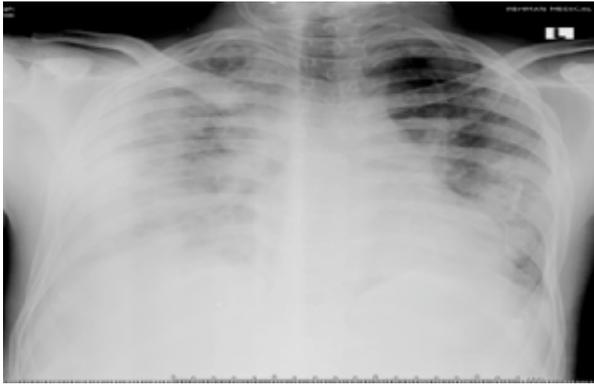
chest X-ray bilateral multilobar consolidation
